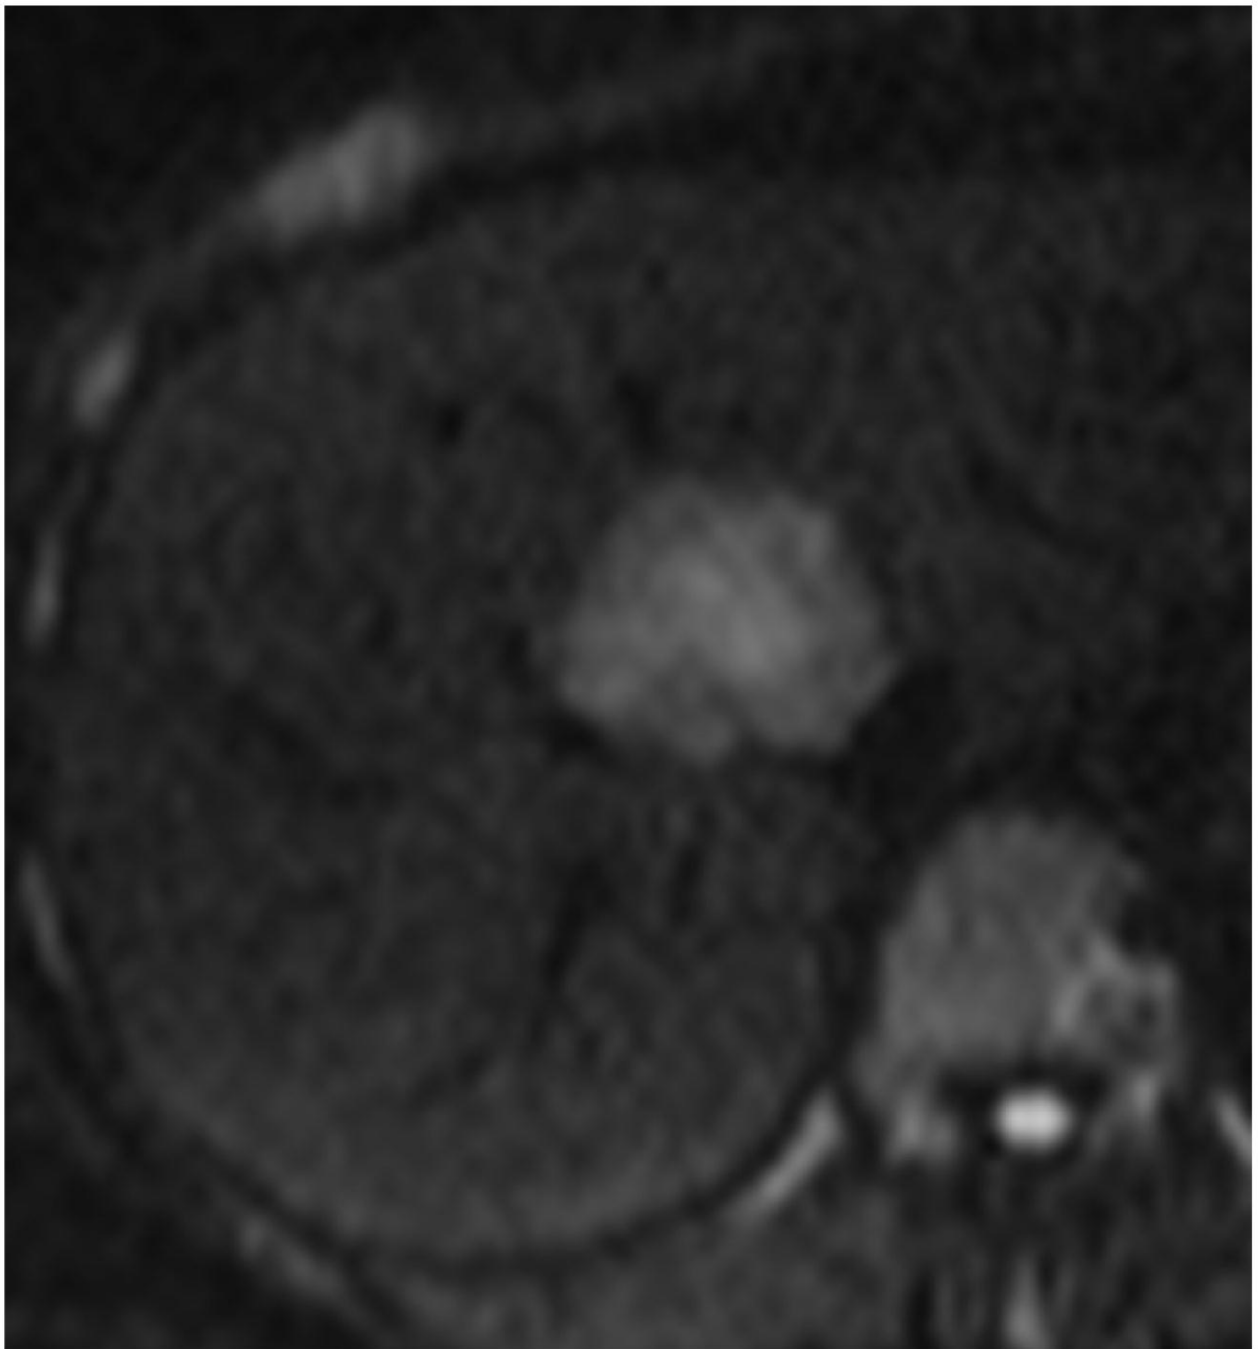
Diffusion-weighted MRI, b-value=400. FNH shows restricted duffusion.
